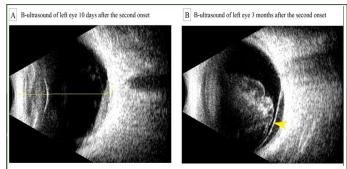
A 63-year-old man suffered from a second subarachnoid haemorrhage 10 days later, (A) B-ultrasound showed vitreous and preretinal haemorrhage of left eye; (B) 3 months later, B-ultrasound showed massive vitreous haemorrhage and limited retinal detachment (yellow arrow head) of left eye.
